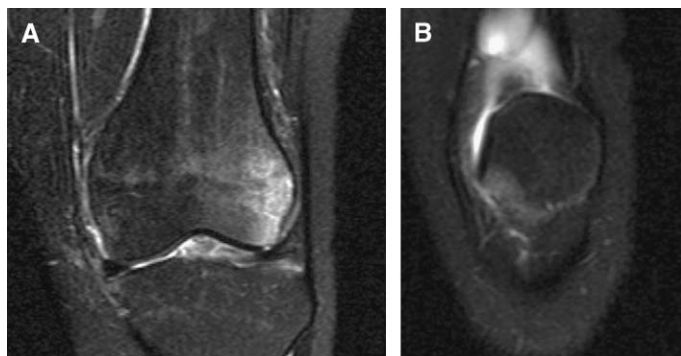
Transient patellar dislocation. T2-weighted fat-saturated images of the knee show marrow edema in the lateral femoral condyle (A) and the medial patellar facet (B).
